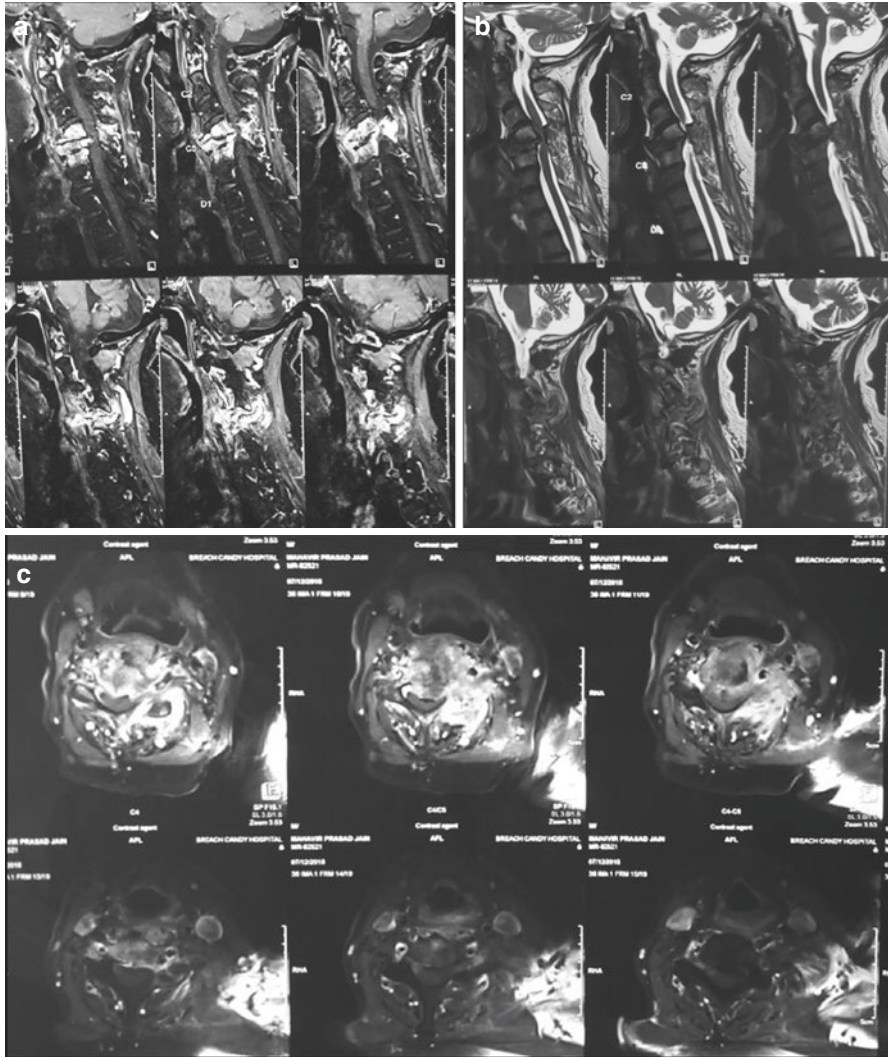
A 75-year-old male presented with progressive quadriparesis for more than a month. Rest pain and weight loss was significant. MRI was showing permeative lesion with collapse in C5 body with rest of spine screening was clean (a–d). X-ray showed C5 body collapse (e). CT scan showed C5 body collapse (f). PET scan showed multifocal uptake in cervical lymph nodes, shaft of humerus, right scapula, and right sphenoid sinus. And were not able to comment on it being neoplastic or infective (g). Post op X-ray after posterior decompression and fixation (h). Biopsy from the site showed it to be drug-sensitive tuberculosis. Thus PET scan still not sensitive enough to differentiate TB from malignancy
